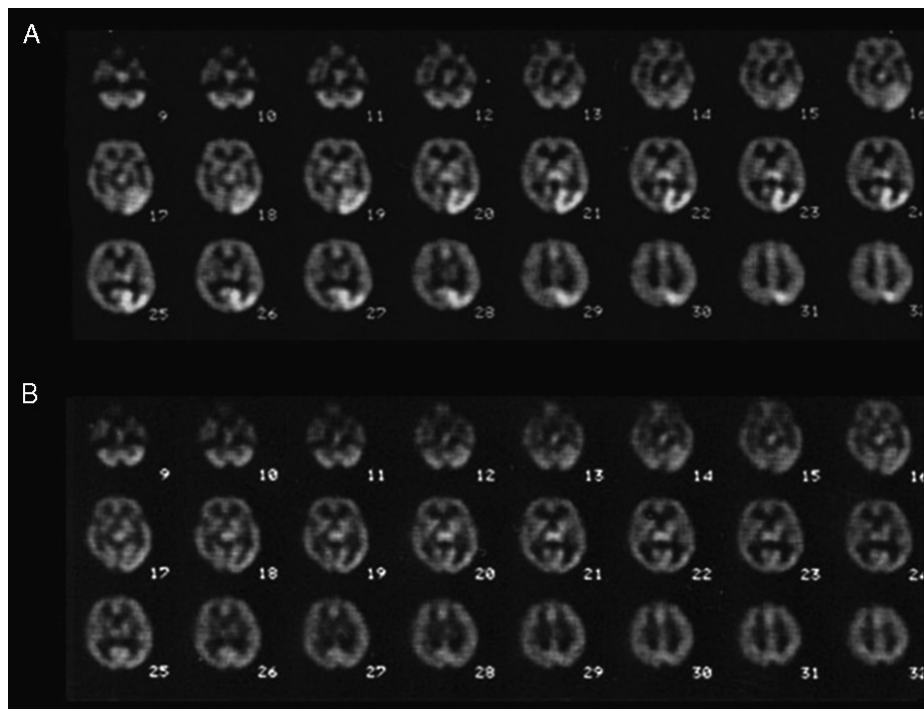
A 55-year-old woman was diagnosed with the syndrome of mitochondrial myopathy, encephalopathy, lactic acidosis, and stroke-like episodes (MELAS), which might be clinically presented with fatigue, short stature, headaches, vomiting, visual symptoms, seizures, paralysis, intellectual disturbance, and even dementia.¹ This patient was referred for ^{99m}Tc -HMPAO brain SPECT studies for further evaluation because she experienced frequent epilepsy-like visual hallucination.^{2,3} To obtain ictal images of SPECT, she was sent to the Department of Nuclear Medicine for observation first and was then injected with radiotracer intravenously as soon as she reported to develop visual hallucinations. A, Transaxial images of ictal SPECT showing remarkably increased regional cerebral perfusion in the left occipital cortex and a very typical ictal SPECT image of epileptic disorders. It had been demonstrated that the serial SPECT studies helped differentiate epileptic from nonepileptic (psychogenic) seizures.⁴ She was given anticonvulsive therapy and was then referred for SPECT again after experiencing no attack of visual hallucination for more than 24 hours. B, In interictal status, the cerebral perfusion in the left occipital cortex significantly reduced to a near-normal level in comparison with the ictal images.⁵ The neurologic manifestations of MELAS were complex, and the SPECT images might show focal hyperperfusion before or during a stroke-like episode because of epileptic activity or metabolic acidosis; and diffuse hypoperfusion might be observed in terminal stages.^{6,7} Visual hallucination could be one of the manifestations of occipital lobe epilepsy in MELAS syndrome.⁸ To the best of our knowledge, the current report was the first one to show ictal SPECT images of a patient with MELAS syndrome presenting with epilepsy-like visual hallucination.
